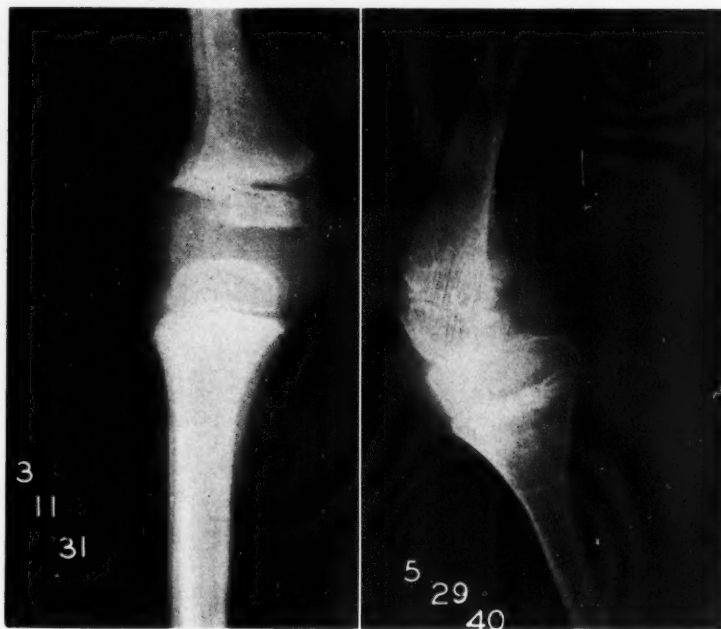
Roentgenograms showing the knee joint at the age of five and fourteen years. Note the ragged epiphyses and broadened diaphyseal lines; also, deformity.
